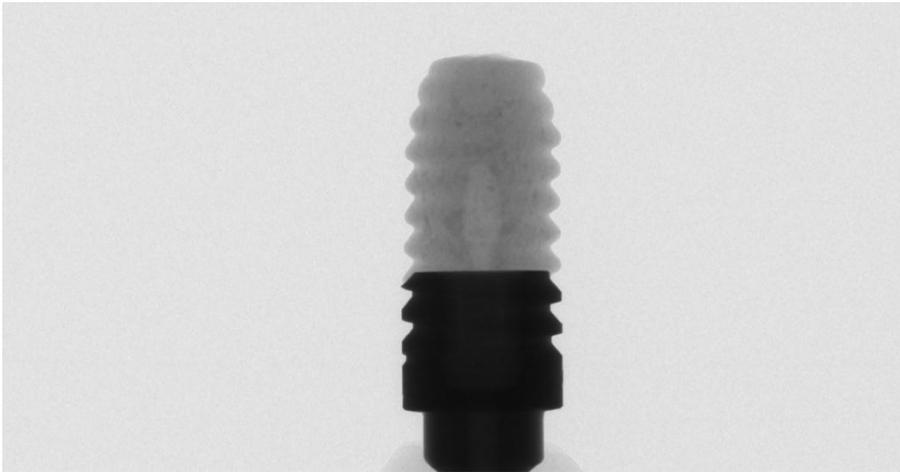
Absorbable implant radiograph
